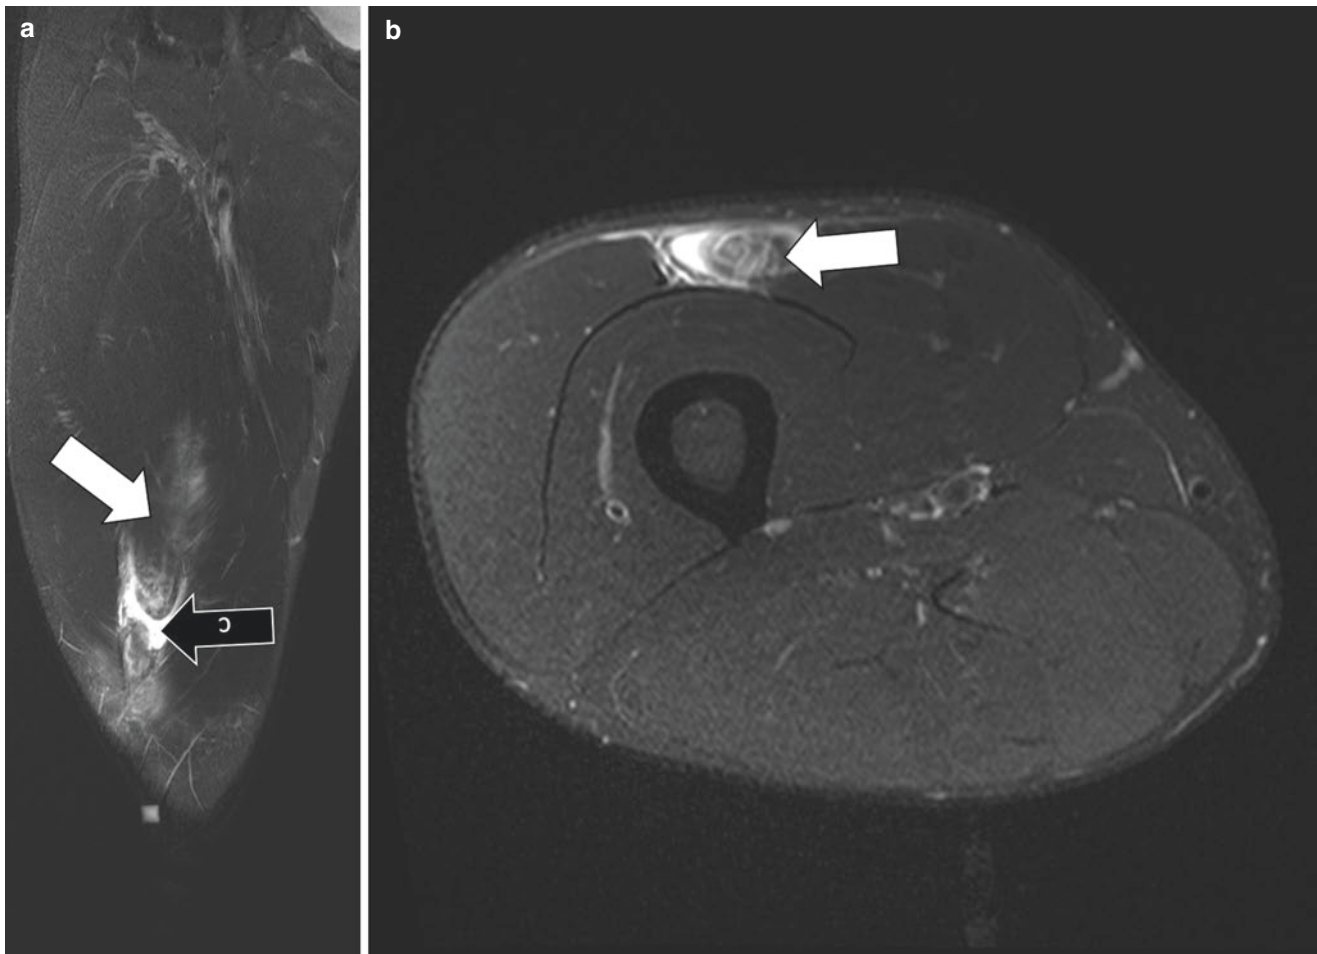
Coronal (a) and axial (b) fat-saturated STIR MR images of the right thigh demonstrate extensive edema in the distal rectus femoris muscle belly (white arrows). This is a grade 3 injury given the complete fiber disruption and retraction apparent on the coronal image (black arrow)
